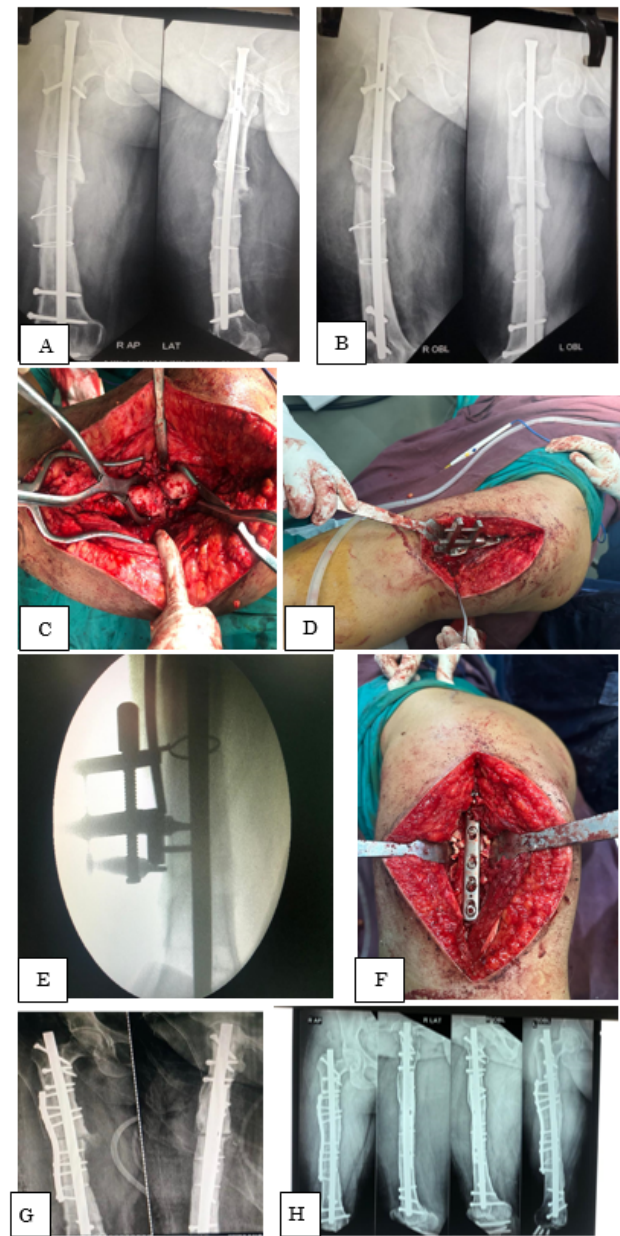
A, B, C): X-ray AP, LAT, OBLIQUE views on Initial presentation of patient with femur non-union with nail in situ with cerclage wires 18 months after primary surgery; C): Fracture site opened with freshening of edges; D): Mullers device over plate used to achieve compression at fracture site; E – C): Arm image showing compression achieved over fracture site with mullers device; F): After application of derotation plate and Allografts at nonunion; G): Immediate postoperative x-ray; H): X-ray showing full union after 18 months in all views
